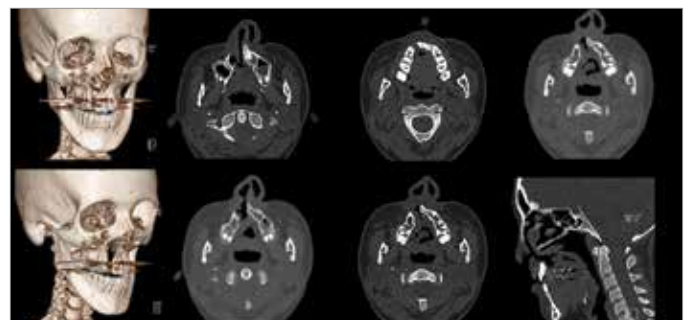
3D CBCT images to evaluate hard and soft tissue facial asymmetries
